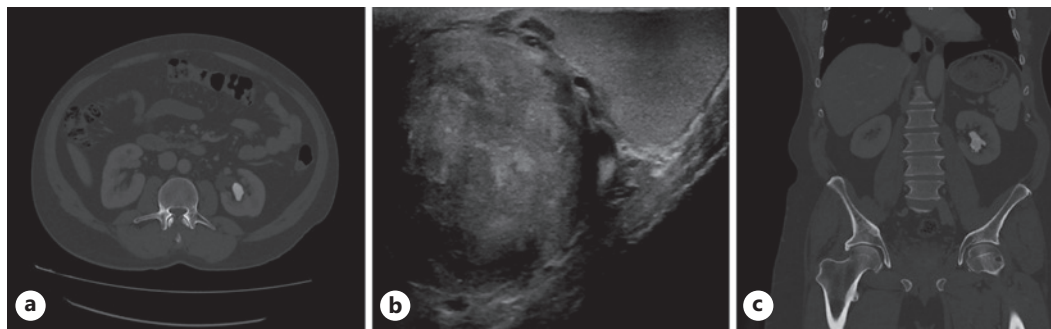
Abdominal imaging showing the staghorn calculus and scrotal mass. a CT KUB showed that the left renal pelvis was occupied by a staghorn calculus. b Ultrasound of the scrotum showing the left epididymal mass of the testis. c Coronal section of computed tomography of the abdomen demonstrated a staghorn stone occupying the left renal collecting system. CT KUB, computed tomography of the kidneys, ureters, and bladder.
